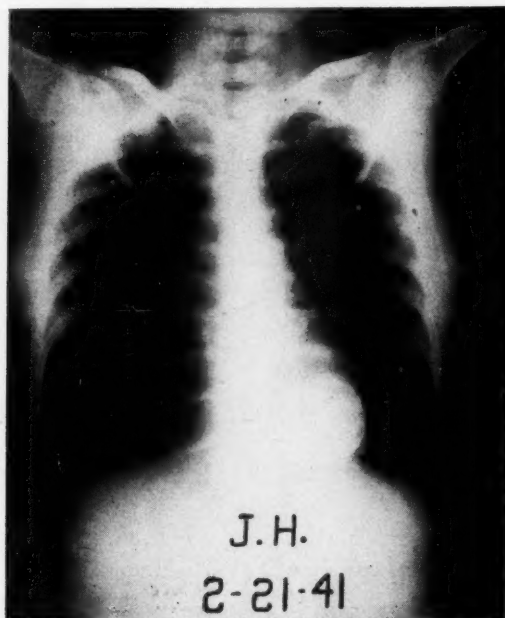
Bucky roentgenogram of chest showing round, partially calcified mass behind the heart. Patient exhibited repeated embolic episodes.
